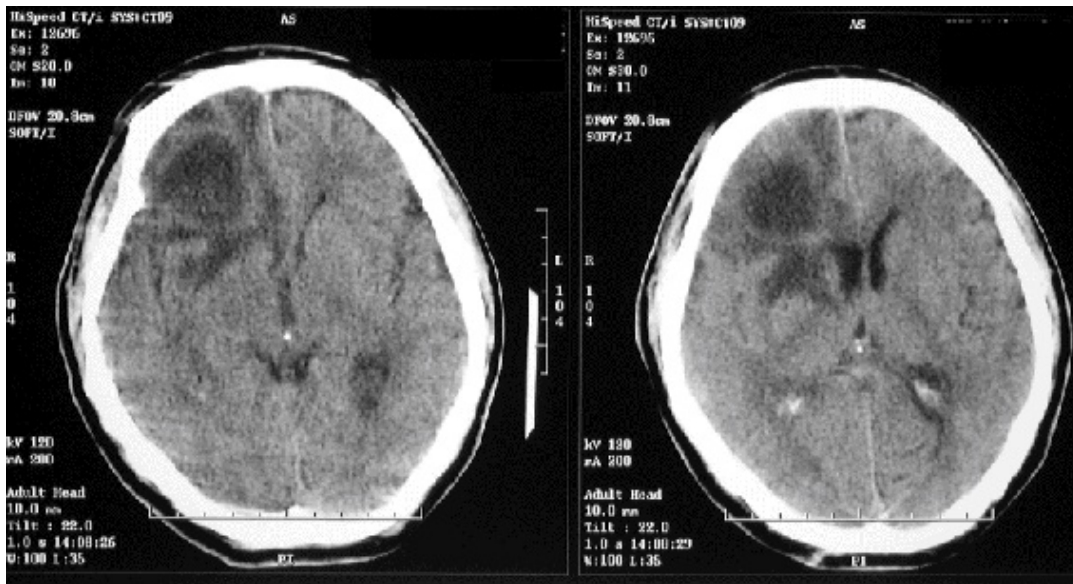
CT Scan Demonstrating Large Cerebral Abscess
